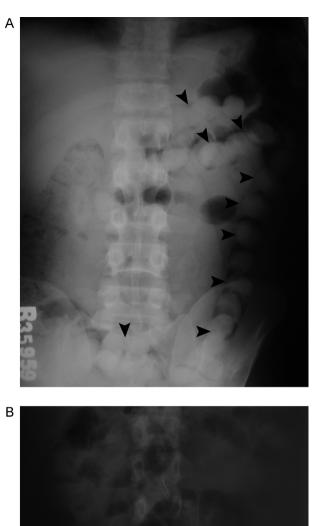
(A) An abdominal radiograph showing multiple ovoid, uniformly shaped intraintestinal type 1 packets (arrowheads). These packets has been correctly identified as type 1 packet by two observers. (B) Plain radiograph of the abdomen of 27-year-old woman who ingested liquid cocaine filled packets. Note that the type 2 packets are not easily distinguished from bowel content in contrast to type 1 packets. This case was misdiagnosed by two observers.
